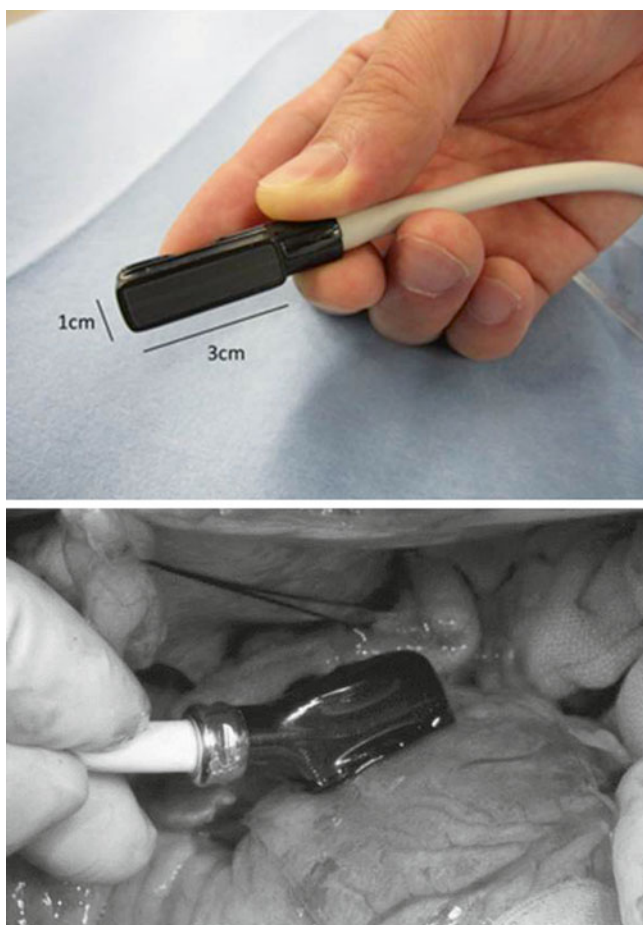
Epicardial ultrasound mini-transducer (*upper panel*). Positioned along the left circumflex coronary artery (*lower panel*)
